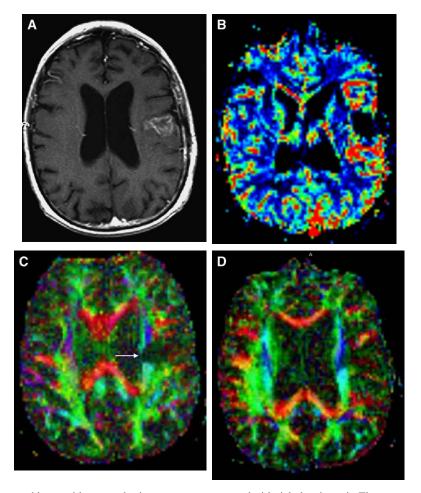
A 56-year-old man with an anaplastic astrocytoma presented with right hemiparesis. The contrast-enhanced T1-weighted image (A) shows a left frontal lesion that has hyperperfusion on the relative cerebral blood volume map (B) (note the black signal caused by excessive enhancement with resulting T1 effect). (C, D) The axial diffusion-tensor imaging—fractional anisotropy maps demonstrate disruption of the left corona radiata (arrow).
